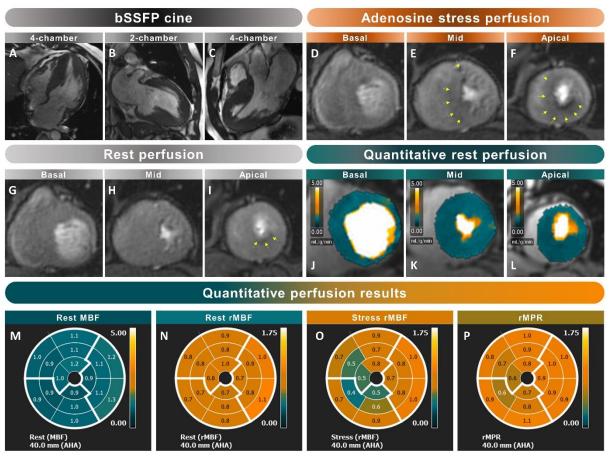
Cardiac magnetic resonance imaging in a patient with hypertrophic
